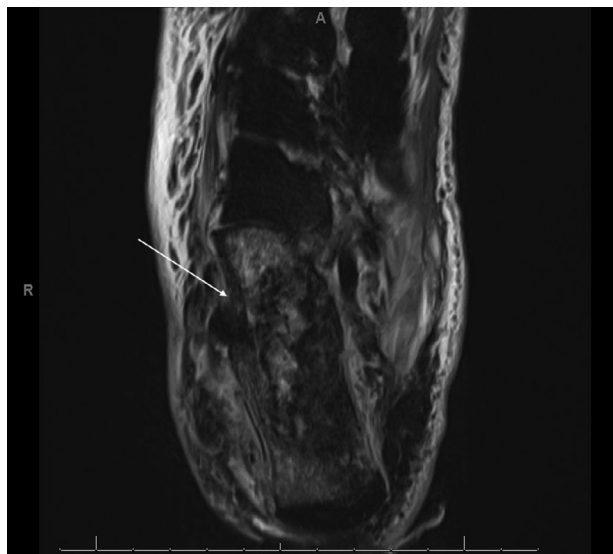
STIR MRI sequence of right calcaneus (coronal view) showing bone marrow edema and surrounding soft tissue edema.
